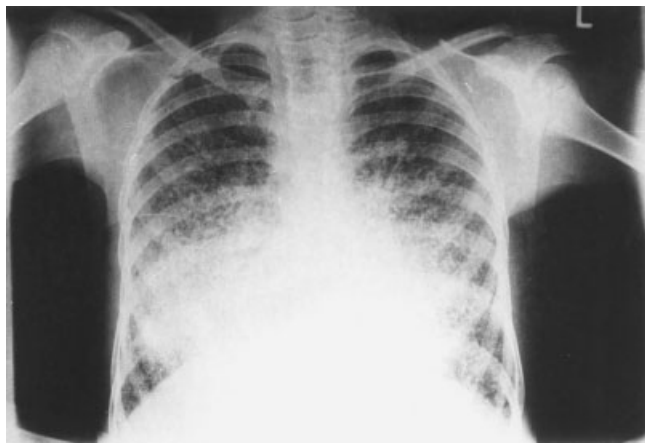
Chest X-ray of 8.5-year-old girl after 18 months of treatment with disodium etidronate. Despite therapy, no radiological improvement was seen (compare with Fig. 1).
